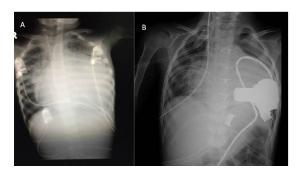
A, Preoperative chest x-ray of patient. B, Chest x-ray of patient with the implanted HeartWare ventricular assist device.
